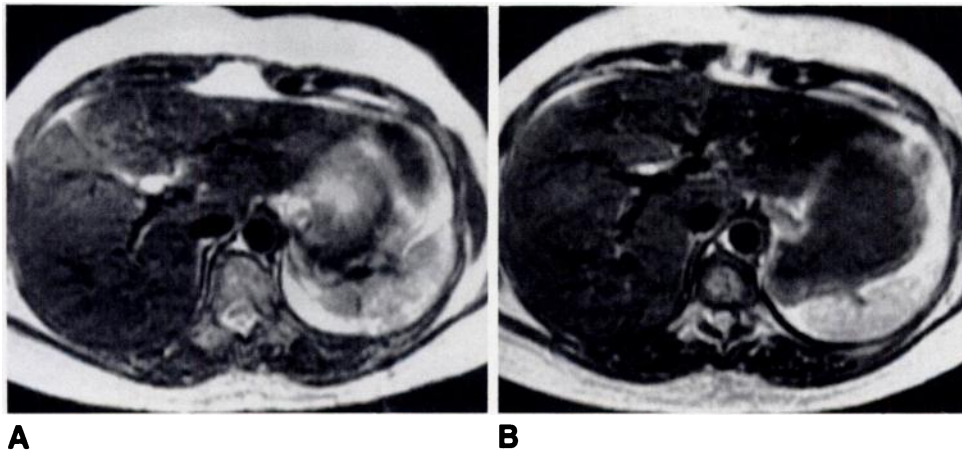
Axial T2-weighted MR images of stomach and left upper quadrant.
